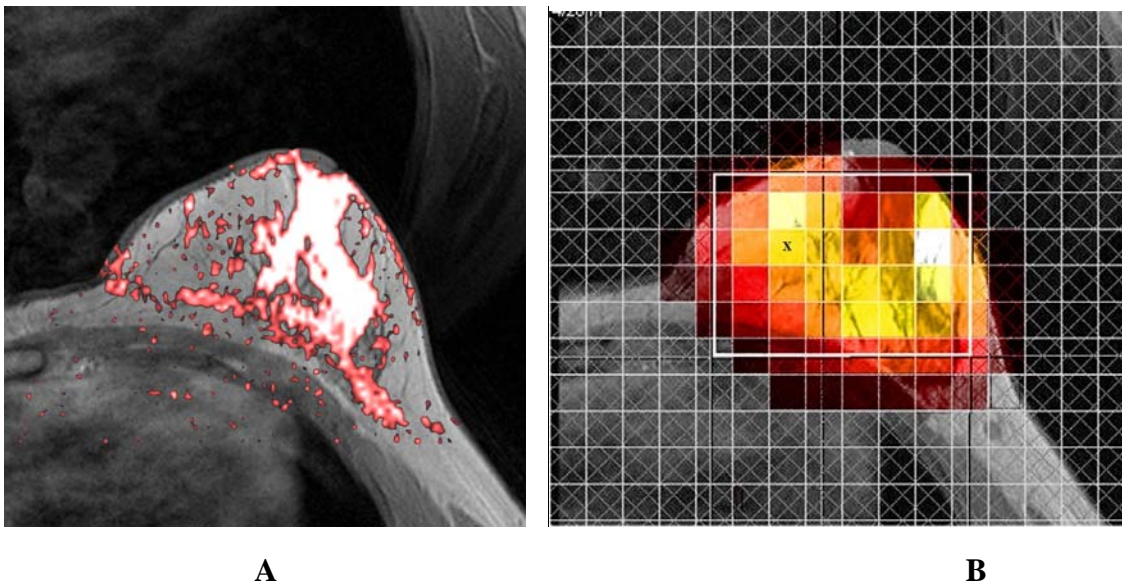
A) An axial ADC slice image recorded in a healthy volunteer using the DWI sequence. B) Axial Fat chemical shift image recorded in the same volunteer using the EP-COSI sequence. Both images are overlaid on top of the T₁-weighted MRI.
